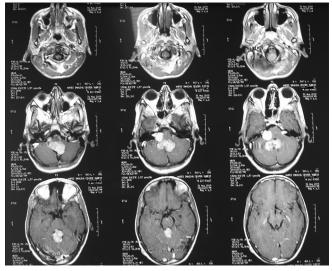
Axial magnetic resonance imaging with contrast: Bilateral acoustic neuroma, and meningioma in $\mathbf{4}^{\text{th}}$ ventricle
